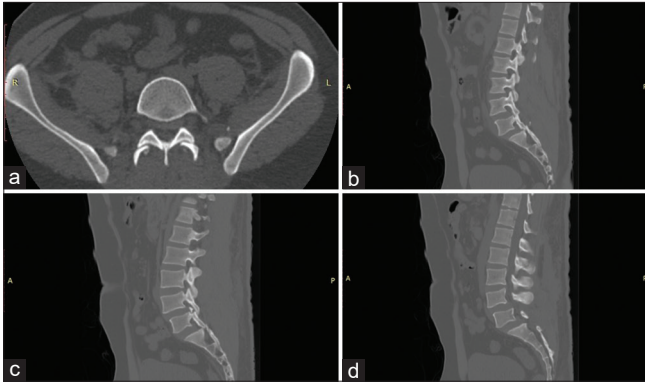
(a) Computed tomography (CT) scan LS spine axial cuts at L5/S1 level. (b) CT scan LS spine sagittal cut at the level of left pars. (c) CT scan LS spine sagittal cut at the level of right pars. (d) CT scan LS spine – Mid sagittal cut.
